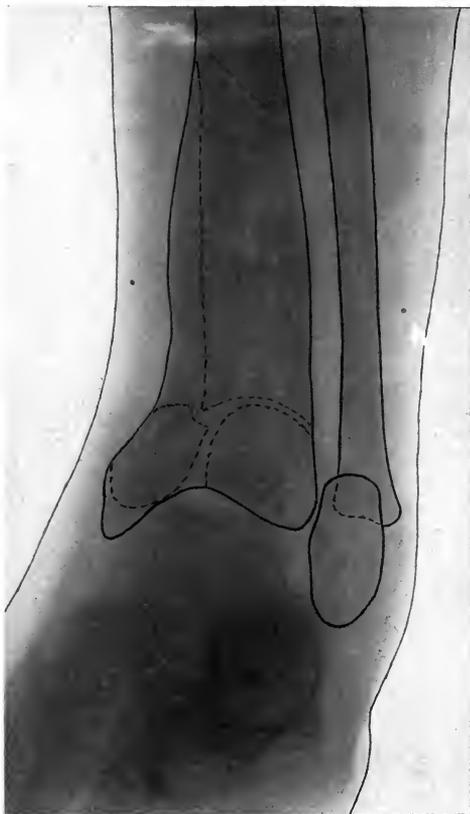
X-RAY OF CASE OF FRACTURE OF BOTH BONES OF THE LEG, THE EXTERIOR PICTURES OF WHICH ARE SHOWN IN FIGS. 203 AND 204.
